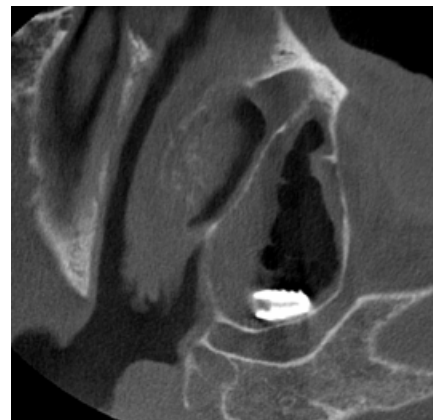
Axial CBCT image
